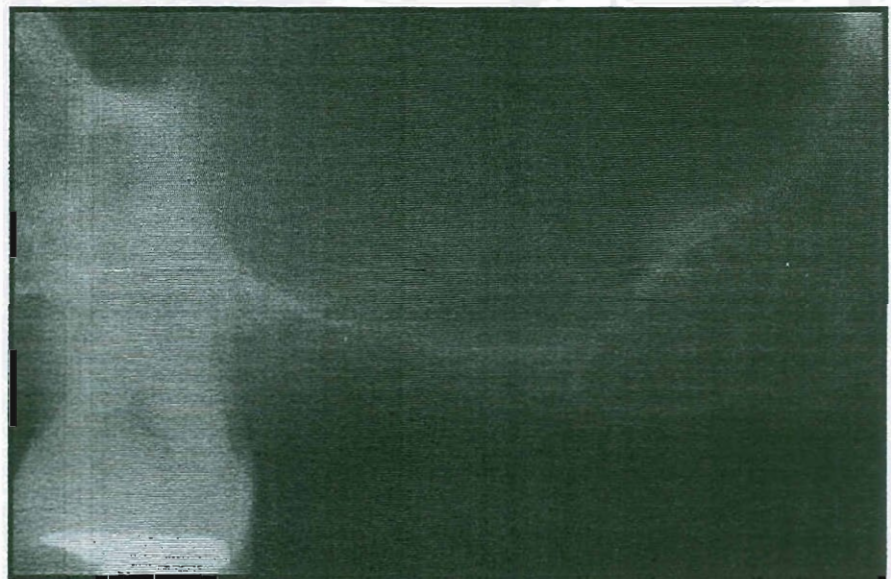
Preoperative radiograph showing the enlarged maxillary sinus. Note the partition of bone remaining following alveolar resorption of the edentulous space.
